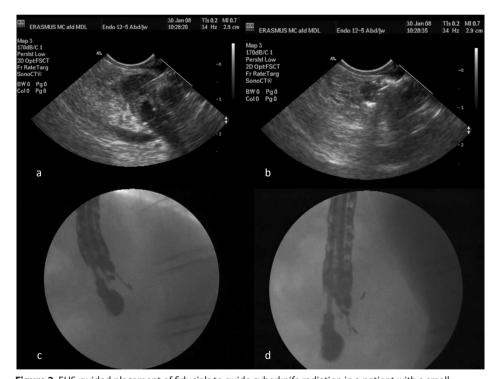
EUS-guided placement of fiducials to guide cyberknife radiation in a patient with a small, cytologically proven, local recurrence of gastric cancer after surgical resection. 2a. EUS-guided puncture of malignant mass lesion close to splenic artery with 19 G needle (white arrow). 2b. EUS guided advancement of fiducial through a 19 G needle with pusher rod. De fiducial has just disengaged from the needle tip and is visualized as a hyperechoic structure with an acoustic shadow. 2c. X-ray image showing a fiducial just being pushed out the 19 G needle. 2d. X-ray image showing the tip of the 19 G needle and 2 fiducials that have already been place inside the mass lesion
